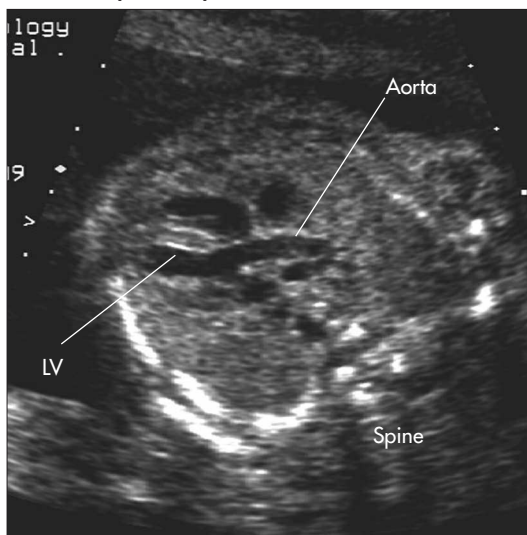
Ultrasound image of the left ventricular outflow tract. The aorta may be clearly seen as it exits the left ventricle (LV).
